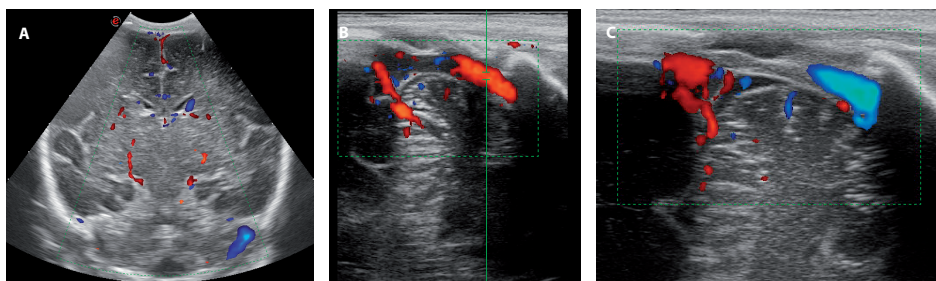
Doppler CUS imaging of transverse and sigmoid sinuses
